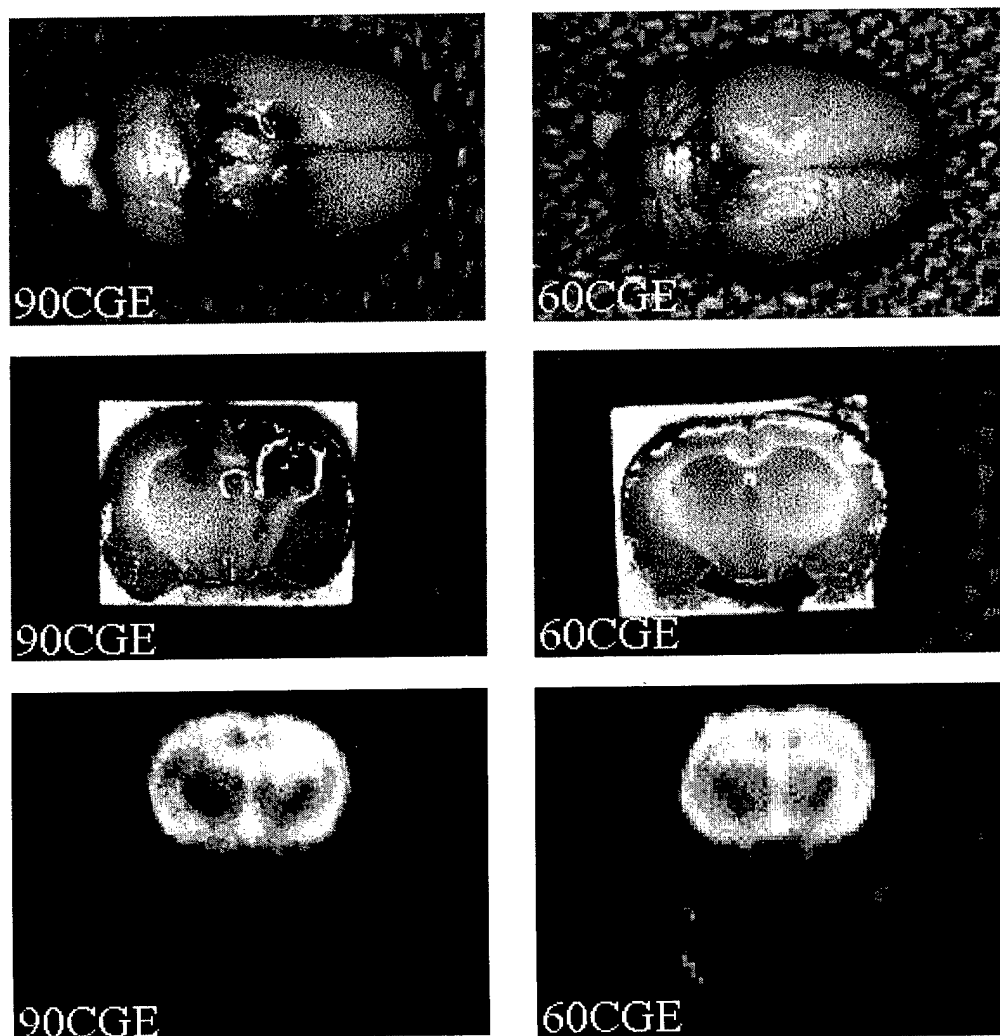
Gross brain: T2 MRI.
